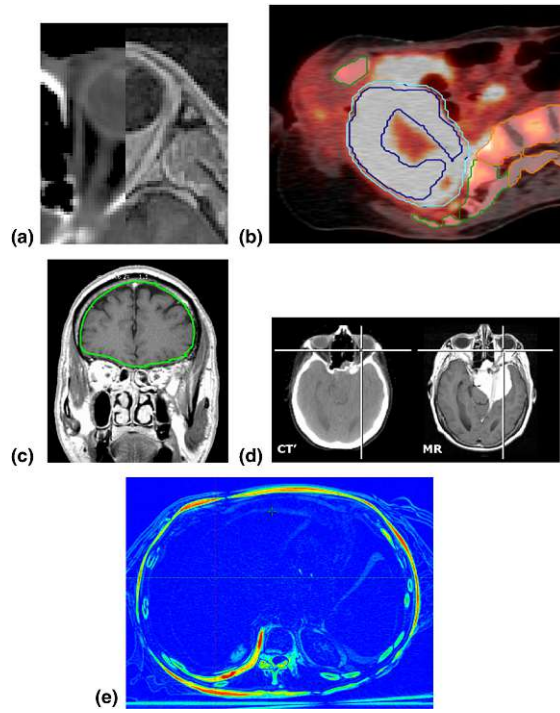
Examples of qualitative measures for evaluation of registration results: (a) Visual validation using split-screen displays of MR and reformatted CT. (b) Region of interest delineation overlaid on a fused PET-CT. (c) Visual geometry validation of overlaid CT brain structure over MR images. (d) Side-by-side display with the linked cursor. (e) Difference image showing good registration in blue and more uncertainty in the bone and surface with yellow, green, red color. (Figure from [10])
